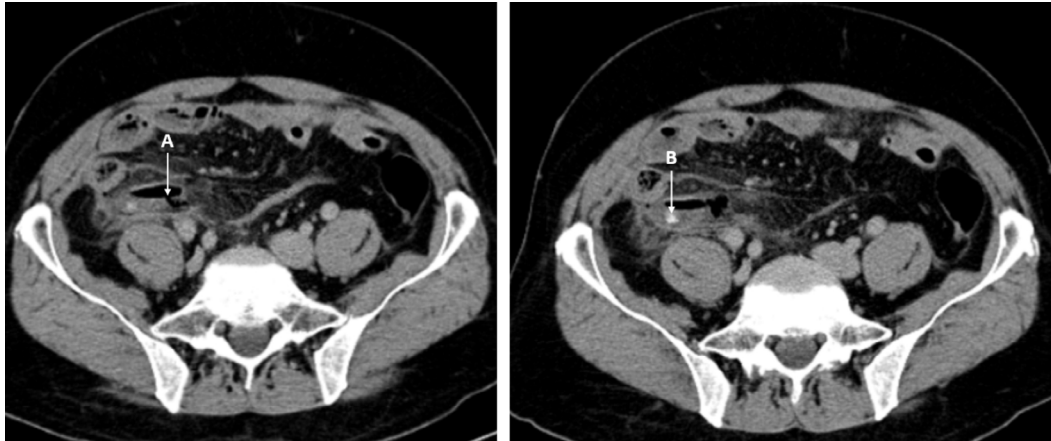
The axial computed tomography images of a 46-year-old male patient diagnosed with perforated appendicitis based on pathological findings, revealing an appendiceal wall defect (a) and an intraluminal appendicolith (b).
